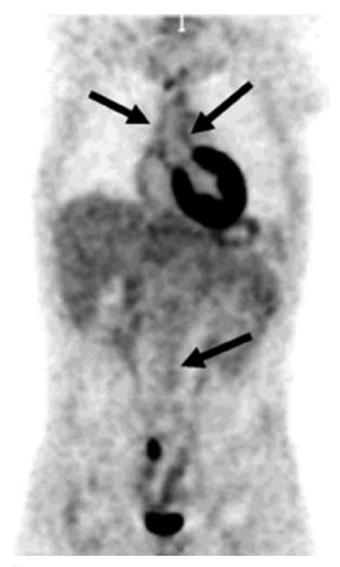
Aortic FDG activity. There is visible FDG uptake in walls of ascending and abdominal aorta (arrows) in this 23-year-old patient. Mean SUVs for ascending aorta were 1.3 and 1.2 for the abdominal aorta. (Reprinted with permission.⁶²)
